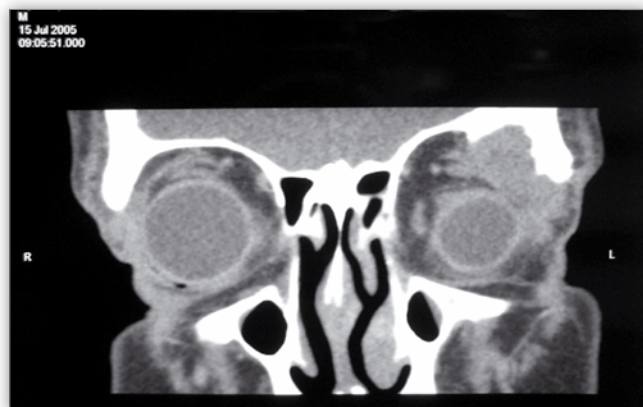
CT scan of the left orbital tumor
